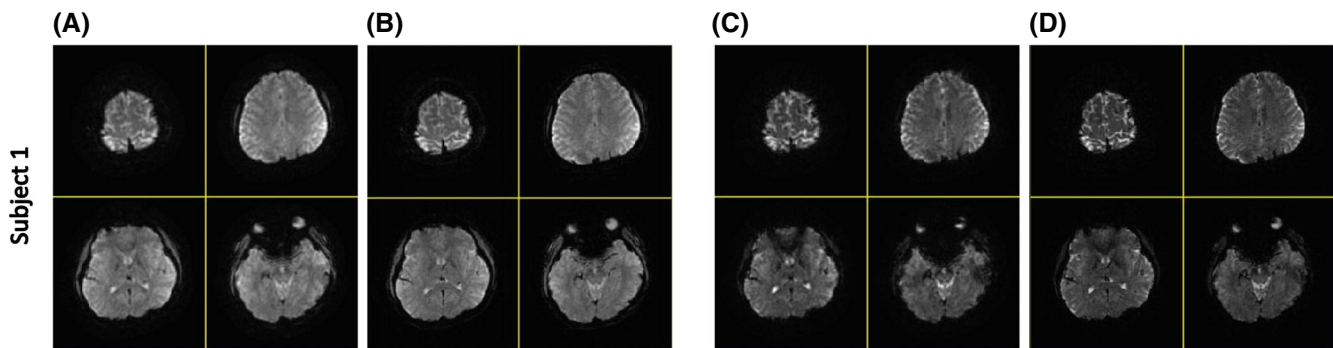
shows the reconstruction for a human brain scan in a representative subject using the high-resolution protocol (1.25-mm isotropic). The structural MRI results using hi-res protocol for the other two subjects are shown in Figure S1 to further support the increased spatial
